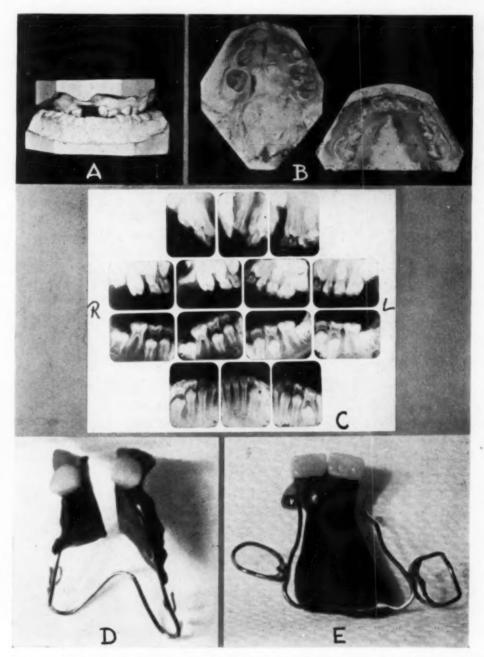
A, Models of teeth in occlusion showing contraction of maxilla and missing premaxilla. B, Occlusal view of models. C, Full mouth x-ray series of teeth revealing cleft on both sides of nasal septum. Sequestrum appears to be present in maxillary central incisor region. D, Original fixed-removable appliance with split plate and teeth. E, Obturator combined with appliance of removable type.
